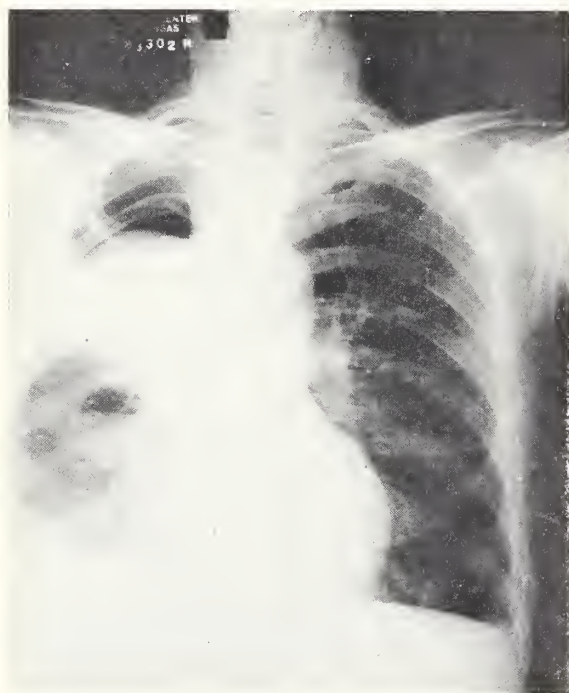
(L.L.) Admission PA roentgenogram. Hydropneumothorax on right with contracted right upper lobe.
